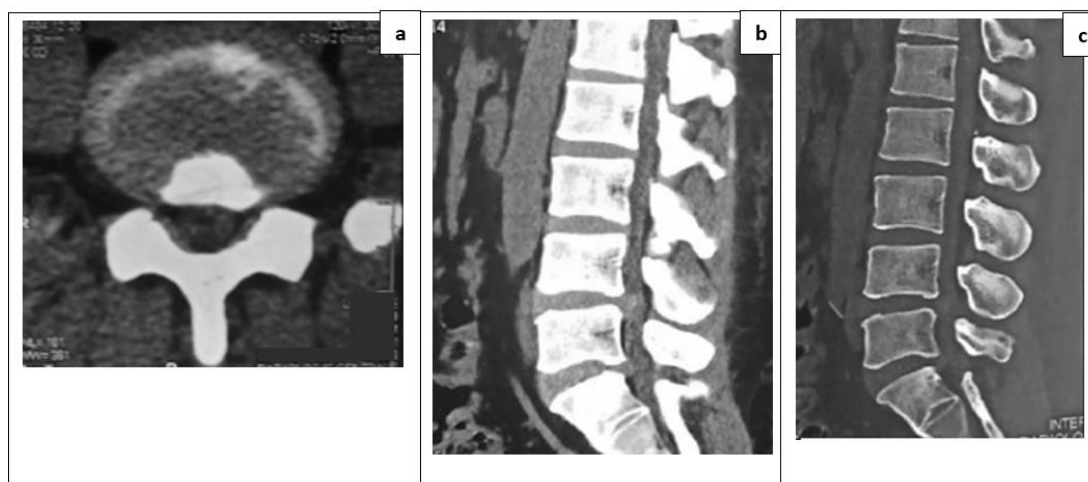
Patient's lumbar CT.
